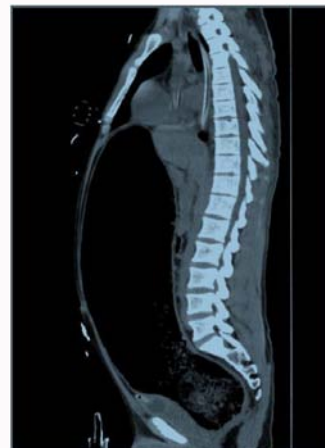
A diagnostic CT scan he was hit by pulse less activity cardiac arrest consequent to severe hyperkalemia.
